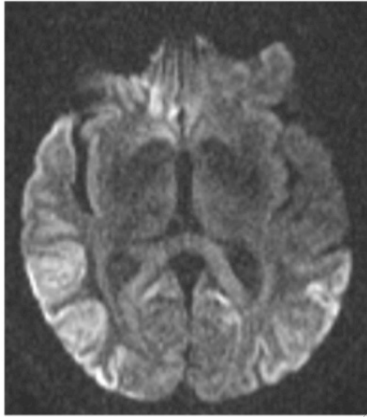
Diffusion-weighted image from the MRI performed in September, 2014, demonstrating extension of the previously documented signal abnormalities, with bilateral involvement of basal temporo-occipital and parietal cortices, more marked on the right (1.5 Tesla)
